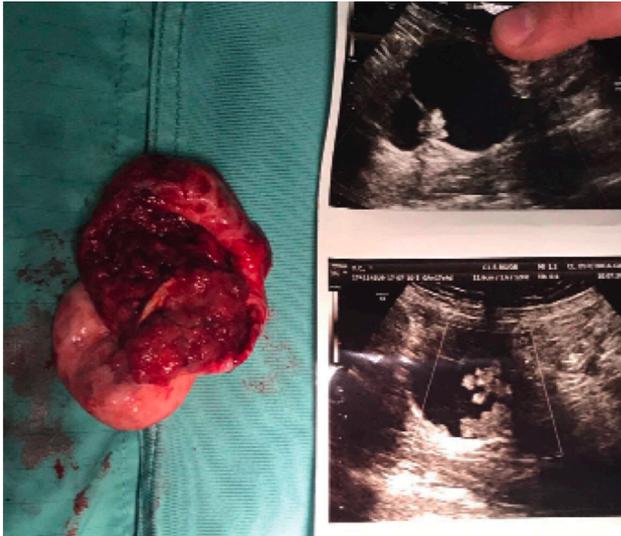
Ultrasound images and cyst.
